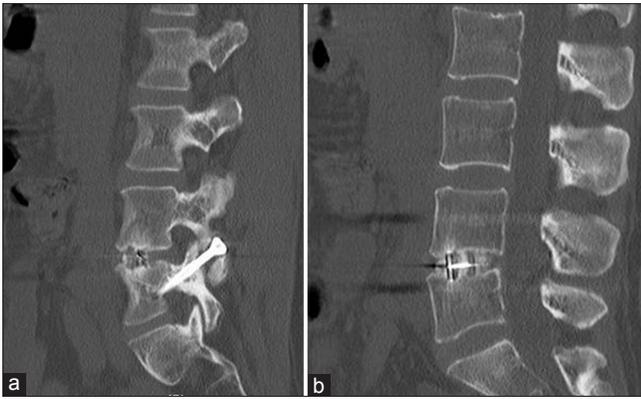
(a) Sagittal CT image to show the transpedicular facet screw into the vertebral body. (b) Sagittal CT image to show bony interbody fusion
